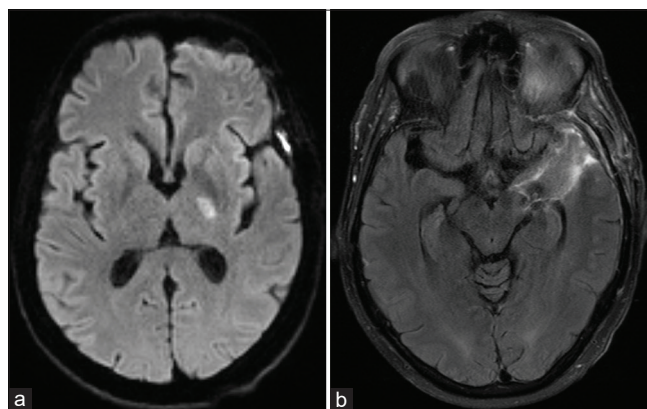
Postoperative MRI brain. (a) Diffusion-weighted imaging demonstrates a small area of restricted diffusion in the left internal capsule. (b) Fluid-attenuated inversion recovery sequence demonstrates postoperative changes of the transgyral approach to the tumor.
